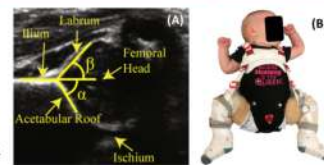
(A) Coronal hip ultrasound¹⁷, (B) DDH Infant testing
